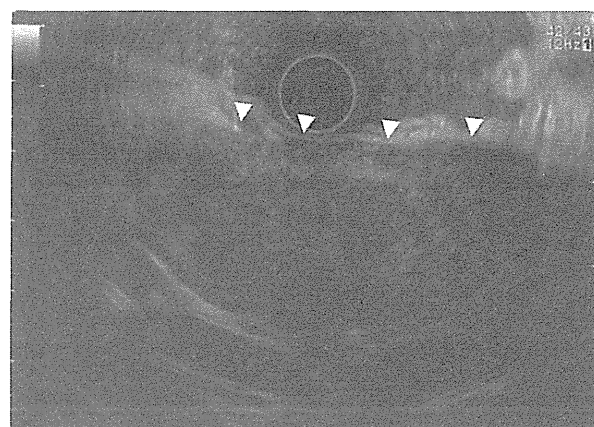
Endoscopic ultrasonography (EUS). Conventional EUS findings show diffuse pancreatic enlargement with a heterogeneous hypoechoic pattern (arrowheads).
